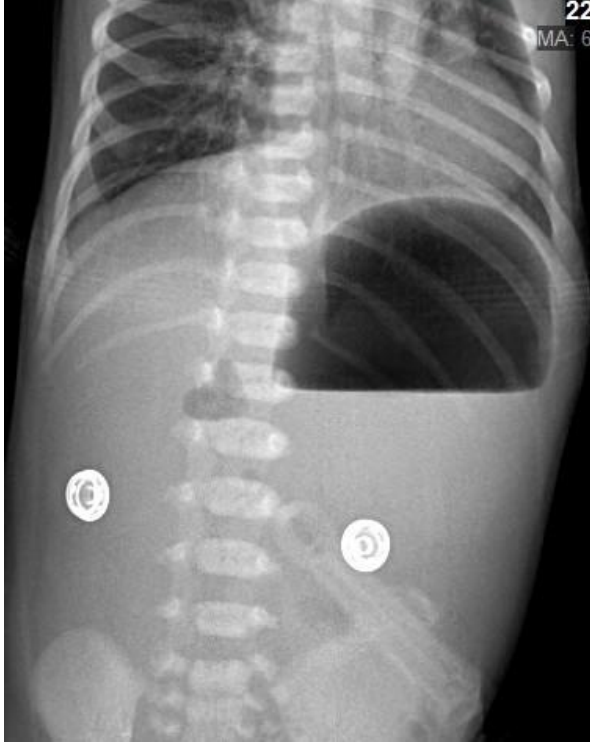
"Double-bubble" sign in plain abdominal X-ray.
